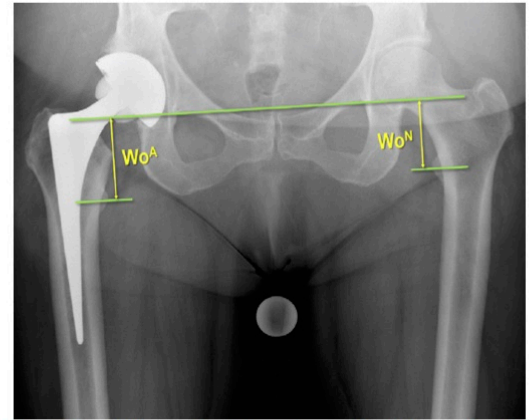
The Woolson et al. technique for measuring LLI on an AP radiograph. The reference line is at the level of the inferior part of the acetabular teardrop. The two further parallel lines are at the level of the midpoint of the lesser trochanter. Measurement W^A for the arthroplasty side is *greater* than the W^N , indicating that the arthroplasty side is longer. Note the contrast with the Williamson et al. method.
